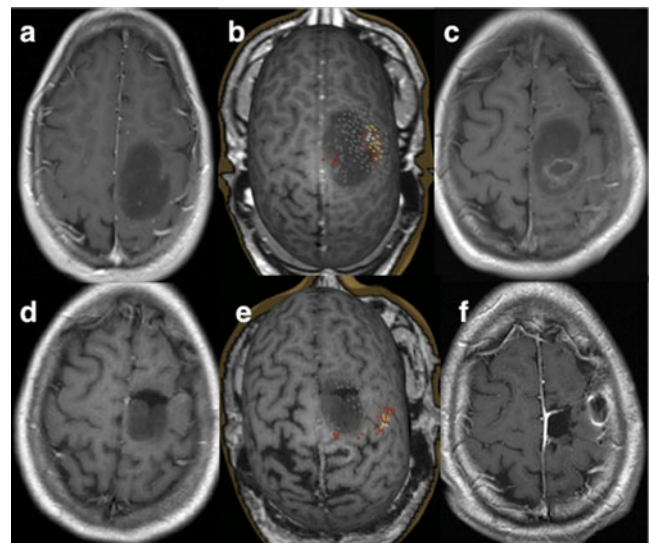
a–c: Before the first surgery: preoperative T1-weighted MR image with intravenous injection of Gd of the tumour (a) low grade glioma spans the precentral gyrus which is outlined by the coloured TMS stimuli (b); this is confirmed intraoperatively and only a partial resection was performed (c) d–f: After 18 months: preoperative T1-weighted MR image with intravenous injection of Gd of the tumour (d) Repeated NBS mapping showed that the M1 has shifted to the post-central gyrus (e) The tumour was resected completely (f). (* On the far right image, lower row (f), note that the area on the tumour side corresponding to the clearly visible hand knob on the healthy hemisphere has been resected)
